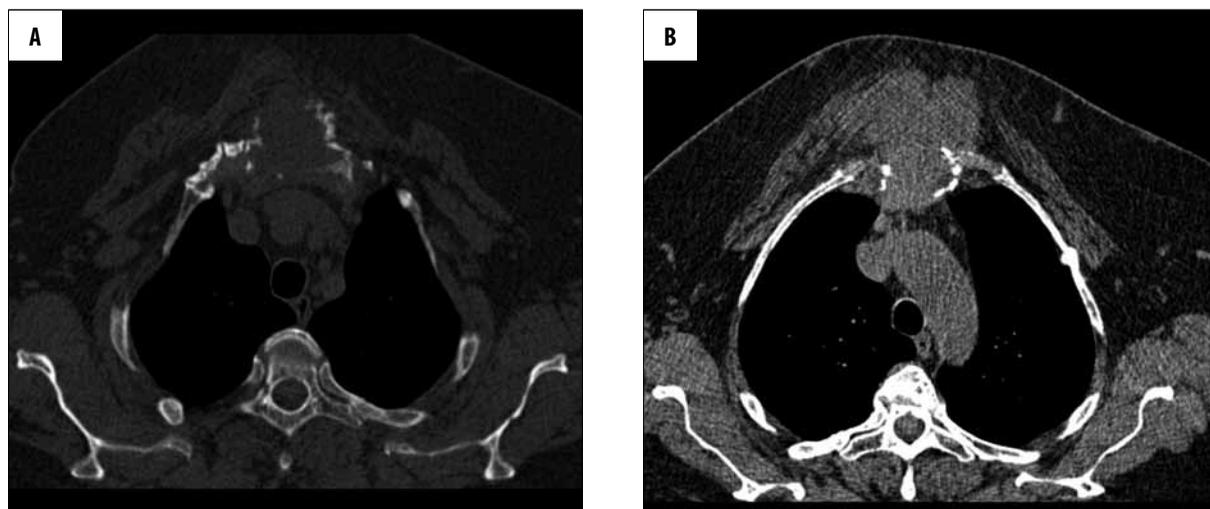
CT scan, axial plane. (A) Bone window. (B) Mediastinal window. Osteolytic area in the sternum filled with soft-tissue mass extending into chest structures.
